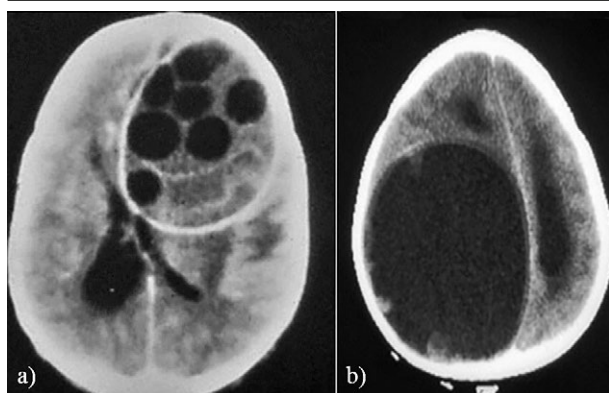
a) Intracranial hydatid cyst type III Gharbi's classification. A 24-year-old man presents with headache and vomiting for the last month: axial contrast CT scan shows a large left frontal multi-locular cyst with presence of daughter cysts. Note the mass effect towards the right frontal horn and right lateral ventricle with shift of midline but without pericysticoedema; b) Intracranial hydatid cyst type I Gharbi's classification. An 8-year-old boy presents with a seizure: axial contrast CT scan showing large right parietal lobe cyst (10 x 8 cm) with thin regular wall, displaying marked compression of left lateral ventricle with midline shift.
